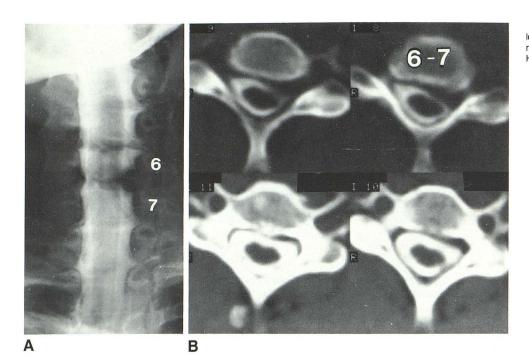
Left C6–C7 HNP. Both myelography (A) and CT metrizamide myelography (B) readily demonstrate left-sided HNP at C6–C7.
